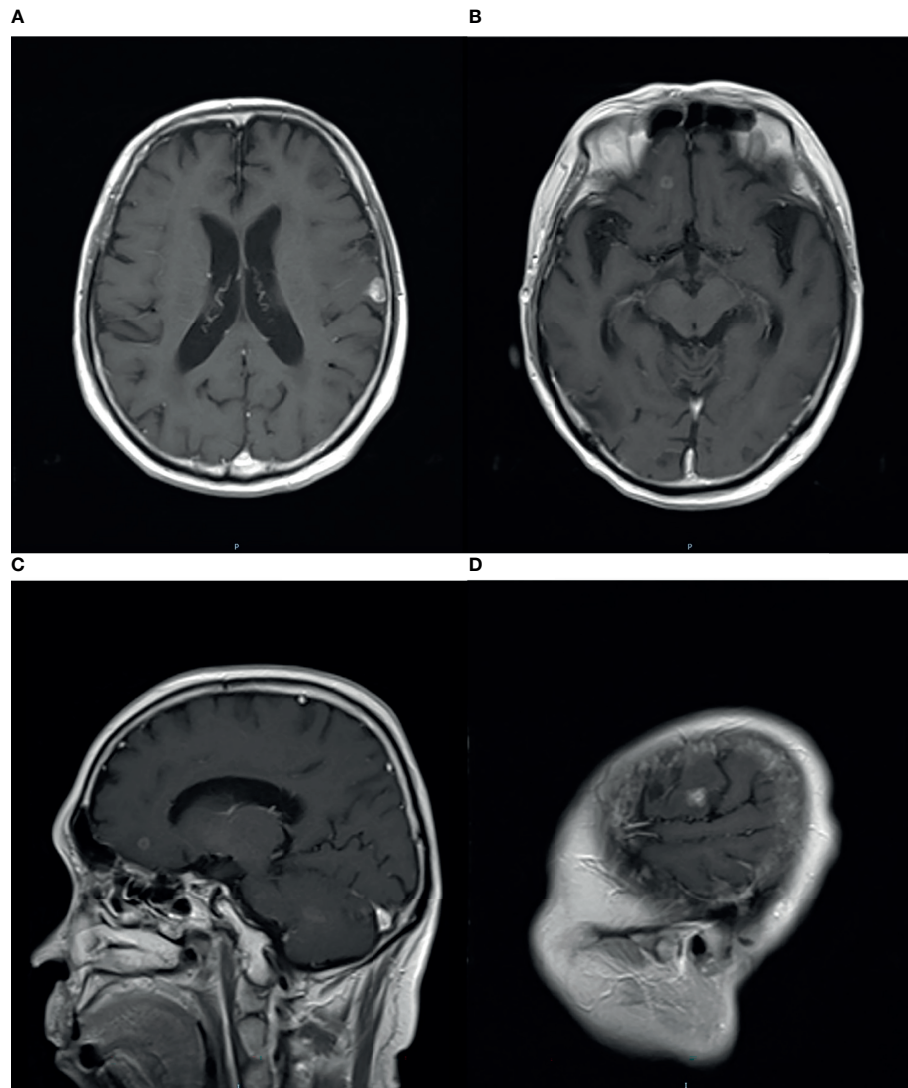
Magnetic resonance imaging (MRI) with contrast enhancement of brain metastasis. (A–D) April 2016, after GK radiotherapy on the brain, new intracranial lesions have been observed.
